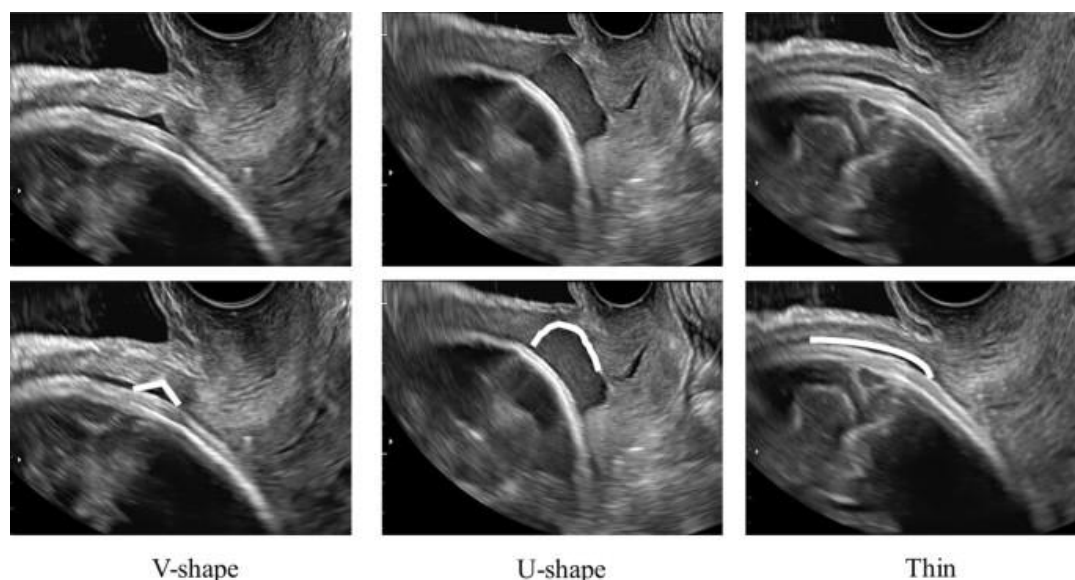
Classification of ultrasonographic images of the lower uterine segment [33]
